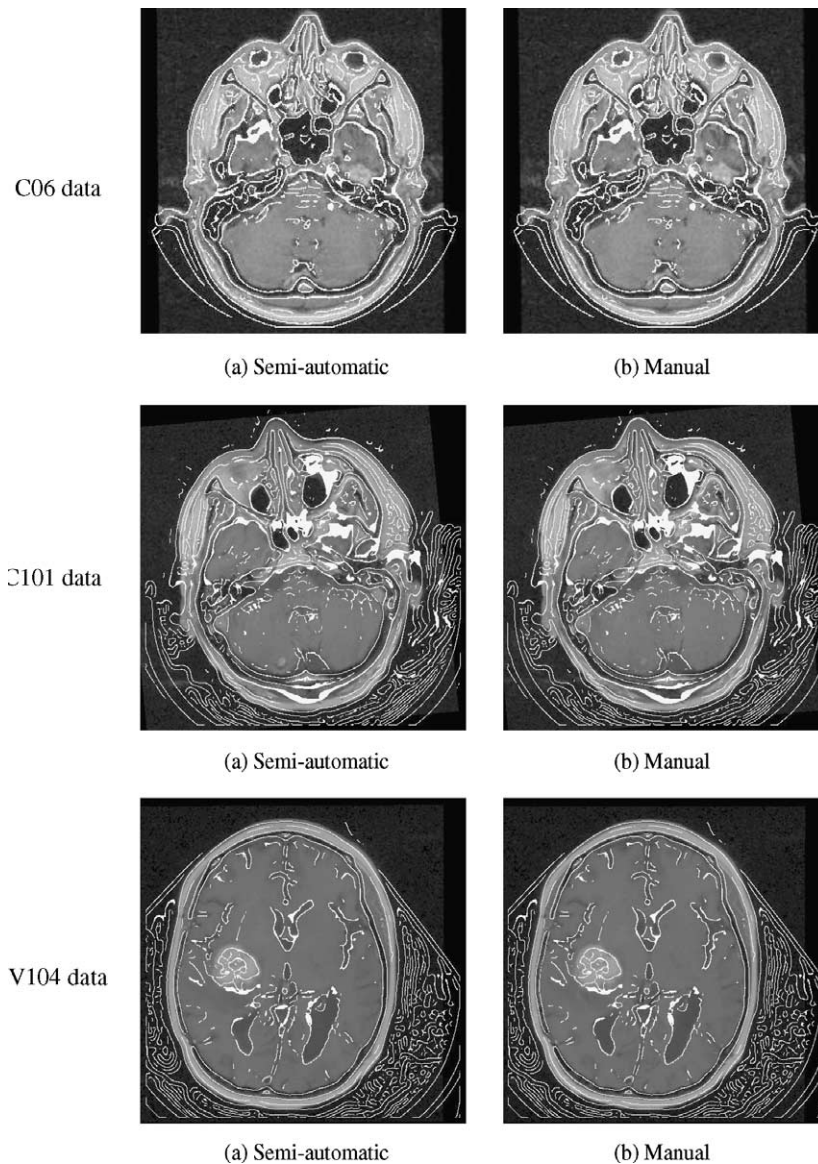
MR/CT rigid registration results based on semi-automatic and manual landmark extraction (for C06, V101, and V104 data and observer 1).
